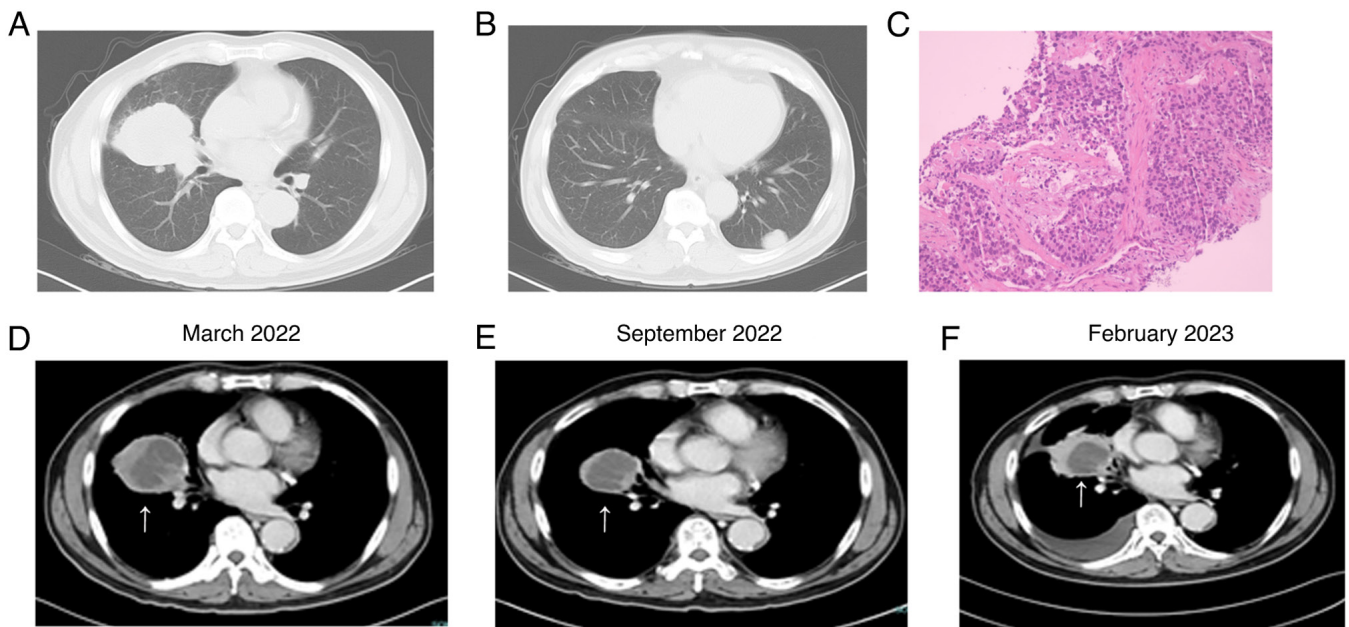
CT images and pathological results of lung cancer. (A) Primary malignancy in the middle lobe of the right lung; (B) metastases in bilateral pleura; and (C) adenocarcinoma. CT scan (D) at baseline (March 2022), (E) after chemoradiation (September 2022) and (F) during follow-up (February 2023). The arrows indicate the primary tumor. CT, computed tomography.
